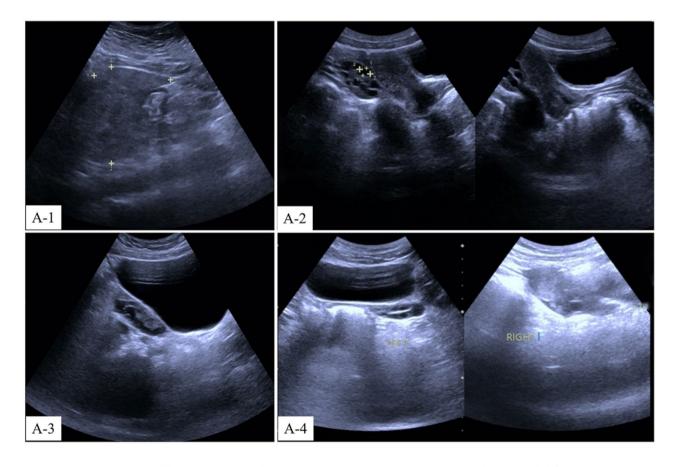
Ultrasound examination of the ovary. A-1: Ovary ultrasound showed multiple anechoic area in bilateral ovaries, well-defined, maximum is about 8\*7 mm (case 1). A-2: Ovary ultrasound showed multiple anechoic area, well-defined in bilateral ovaries, maximum 8\*6 mm (case 3). A-3: Ovary ultrasound showed increased multiple anechoic areas in ovaries (case 6). A-4: Ovary ultrasound showed multiple anechoic area in bilateral ovaries, well-defined, maximum of the right side about 8\*7 mm, the left side about 9\*6 mm (case 8)
